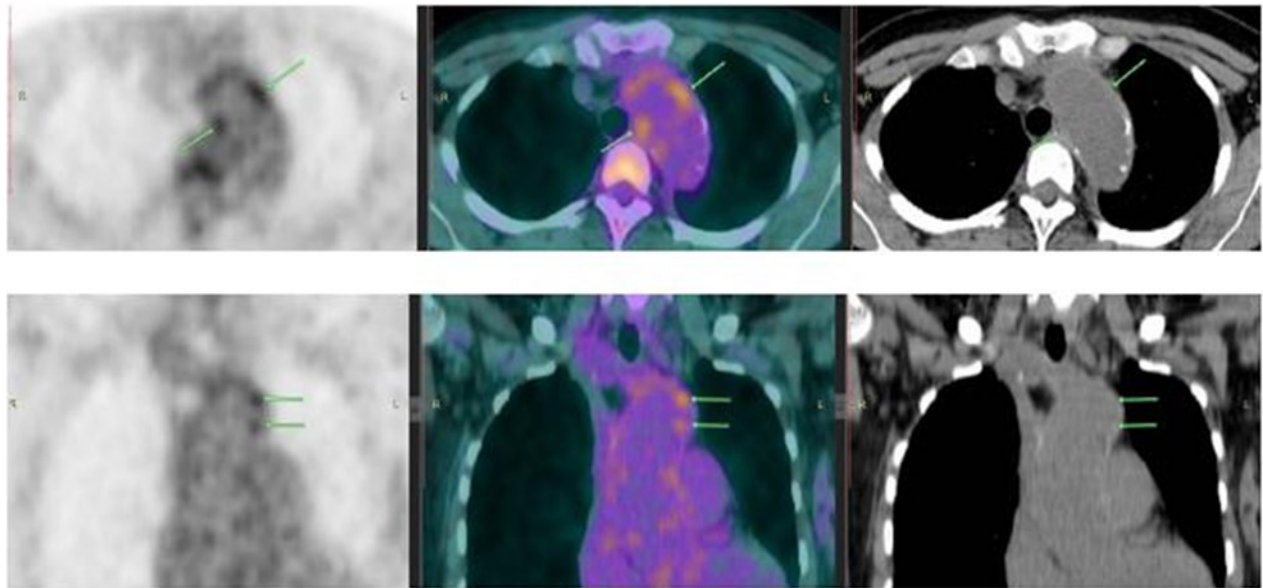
F18-FDG PET (leftmost column), PET-CT fused (middle column), and CT (rightmost column) images showing heterogenous radiotracer uptake in the arch of the aorta with associated enhancement (arrows).
